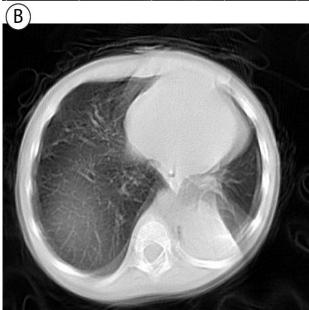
Non-contrast CT scan revealing a suspicious mass in the posterior mediastinum, initially raising the possibility of lung sequestration.
